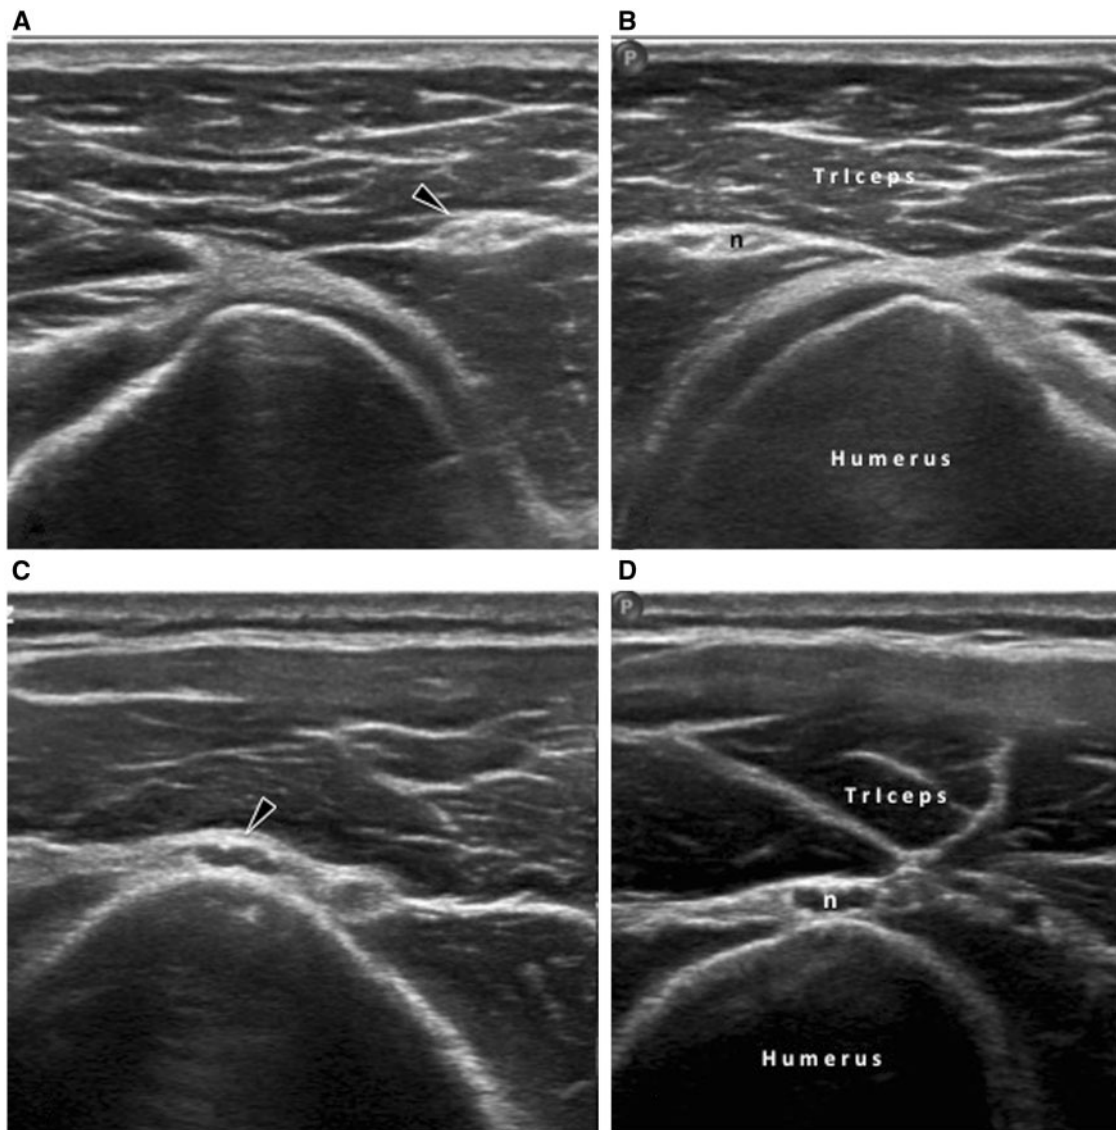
Transverse ultrasound imaging of the swollen (arrowheads) and normal radial nerves (n) before its bifurcation and at the spiral groove. Affected sides (A,C). Unaffected sides (B,D).
